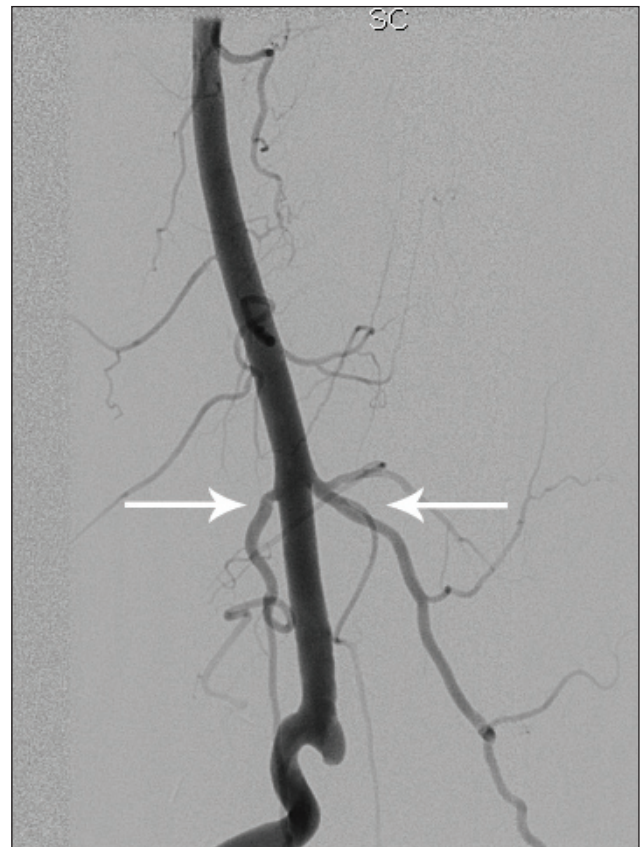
Preoperative CT angiography aiming at the identification of superior genicular branches origin (white arrows).
